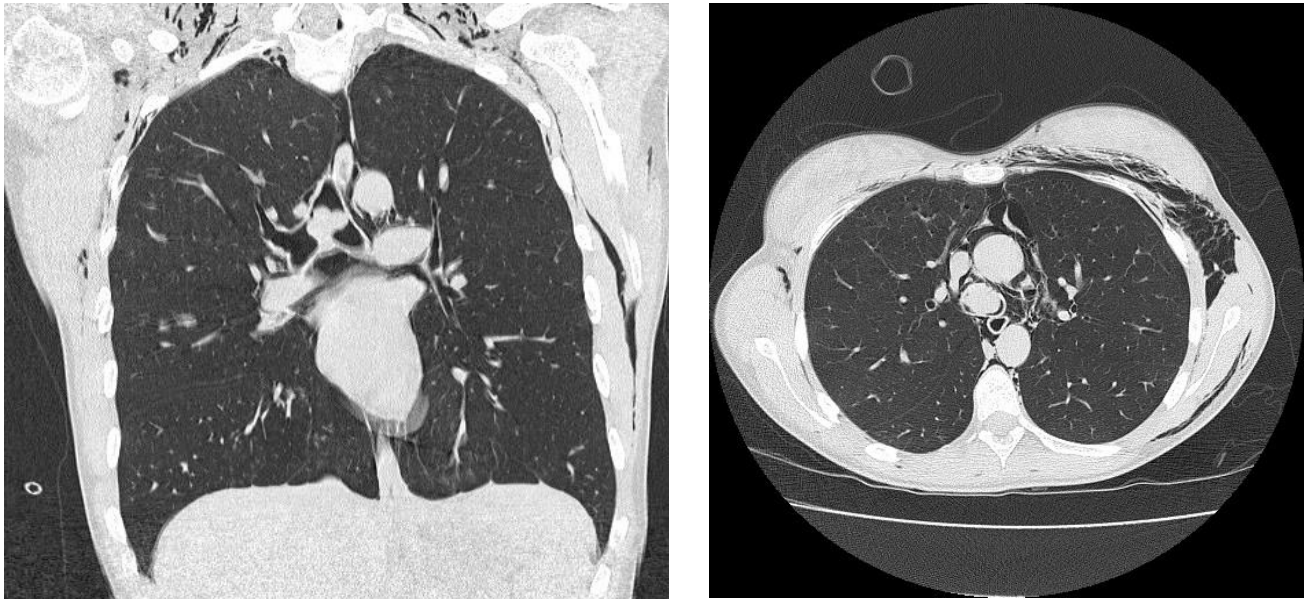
Chest CT showing the endobronchial mass occluding the trachea and both main bronchi (coronal section, left panel; transverse section, right panel). Diffuse subcutaneous emphysema is also evident.
